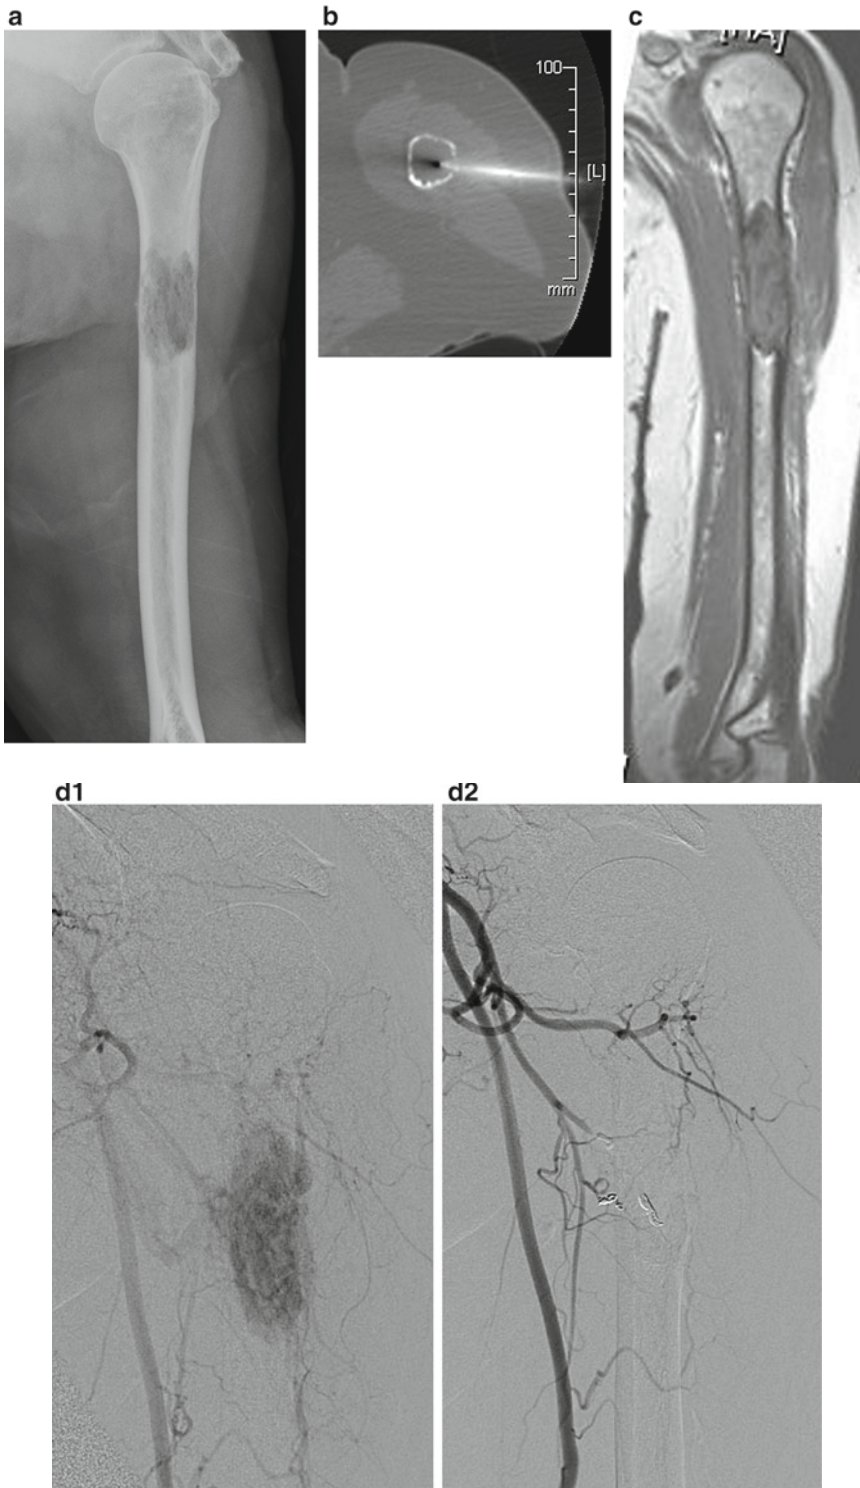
A 69-year-old male with left shoulder pain and a remote history of scalp melanoma. (a) Radiographs demonstrated a destructive diaphyseal lesion of the proximal humerus. (b) CT-guided biopsy demonstrated clear cell
